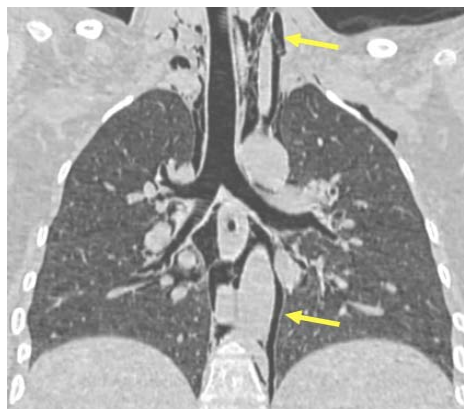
Coronal Chest CT in lung window image demonstrating diffuse pneumomediastinum and neck emphysema (arrows) with no evidence of pneumothorax.
